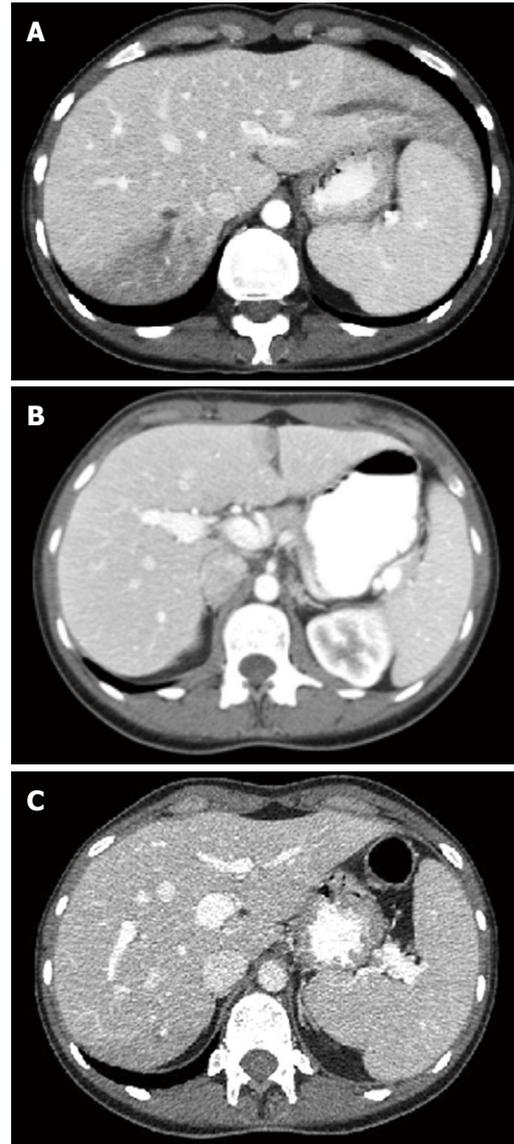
Abdominal computed tomography scans of patient at time points indicated. A: Abdominal computed tomography (CT) scan of the patient on admission demonstrates clear evidence of hepatic vein thrombosis; B: CT scan of the abdomen performed two months prior to admission revealed no evidence of hepatic vein thrombosis; C: Partial resolution of hepatic vein thrombosis two months after admission and initiation of anticoagulation.
